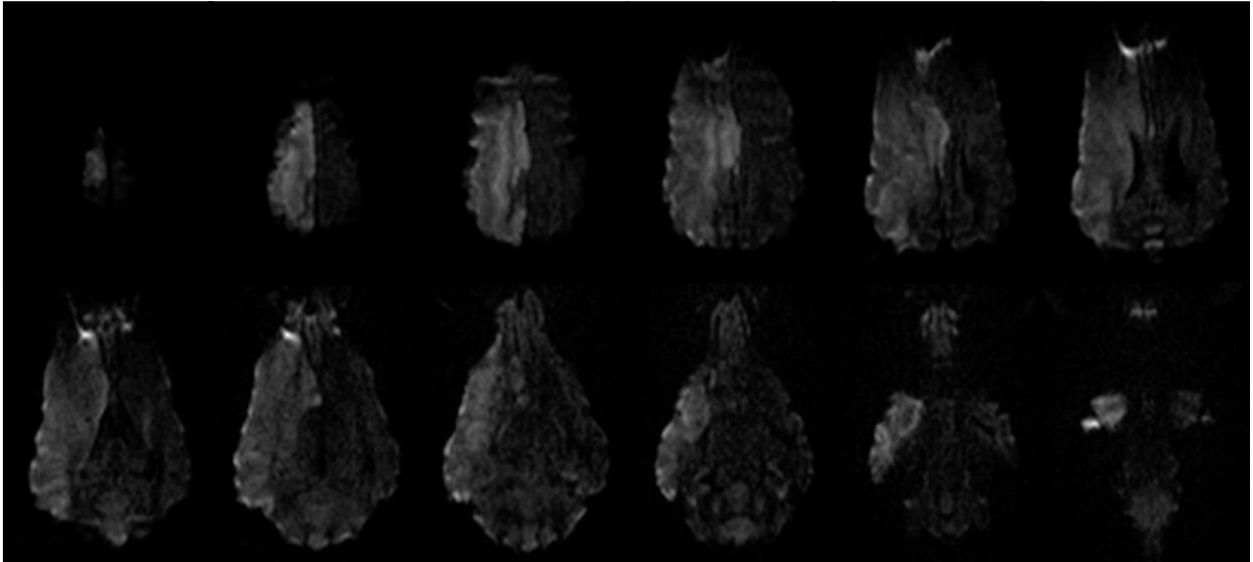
T2 Weighted MRI imaging allowed for quantification of infarct volumes following MCAO
